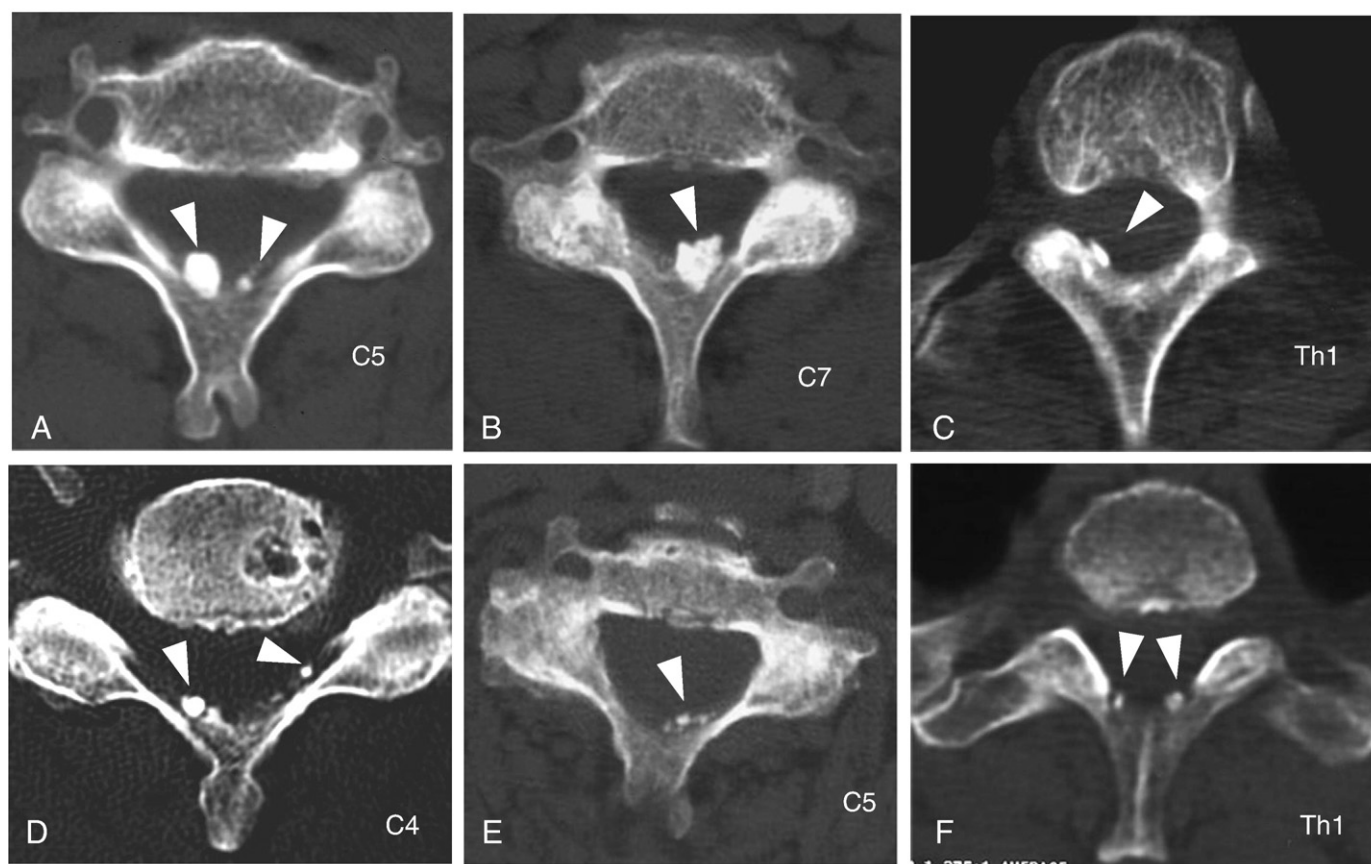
Axial view of the cervical CT scan showed nodular calcifications of the ligamenta flava. (A, B) Patient 1. (C) Patient 2. (D) Patient 3. (E) Patient 4. (F) Patient 8. The levels of the spine are indicated at the bottom right corner of each figure.
